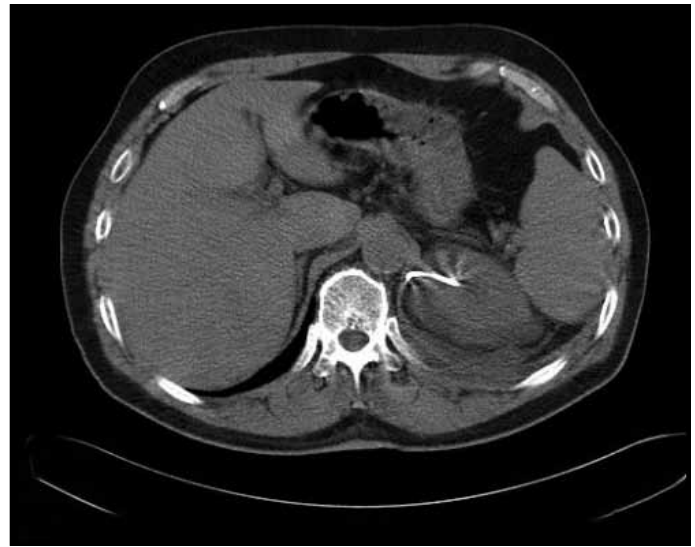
Renal parenchymal perforation on the medial side and perirenal hematoma on the posterior kidney with the proximal end of a double-J stent on non-contrast CT imaging
